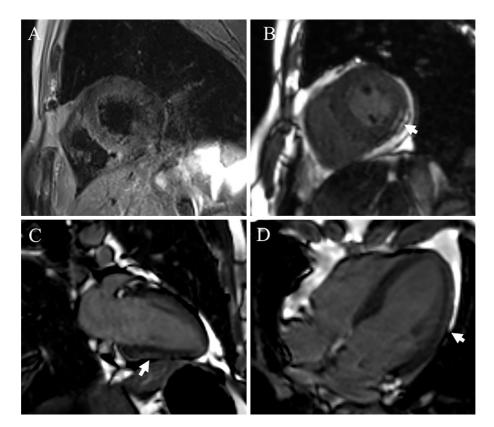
Cardiac magnetic resonance imaging showed a high signal of T2-weighted black blood in the anterior, interventricular septal, and posterolateral walls of the LV (A, short-axis) and late gadolinium enhancement in the posterolateral wall of the LV (B: short-axis view, C: long-axis view, D: four-chamber view; arrows).
